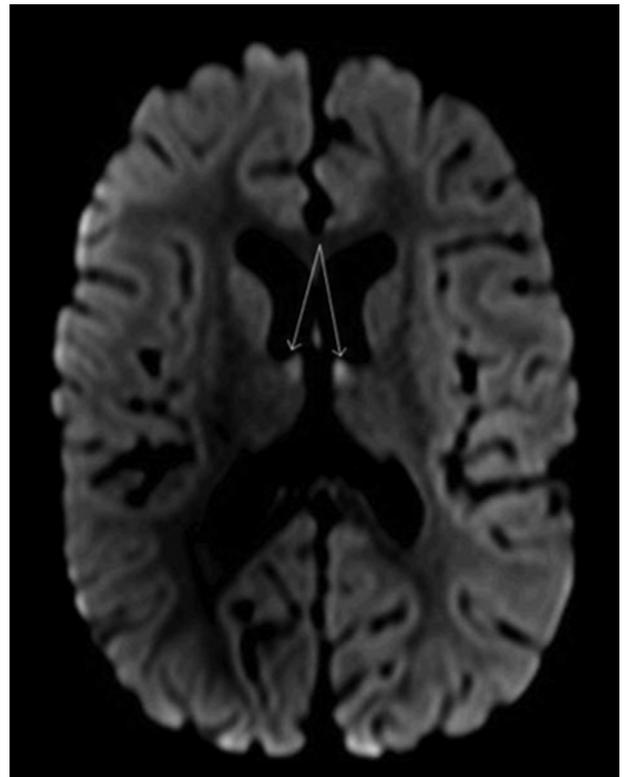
Brain magnetic resonance imaging at eight months of age. On diffusion-weighted imaging sequence, symmetric small foci of restricted diffusion are seen in the medial thalami (arrows). These changes were suspected to have occurred secondary to vigabatrin use. Otherwise, the brain was structurally normal. The color version of this figure is available in the online edition.
